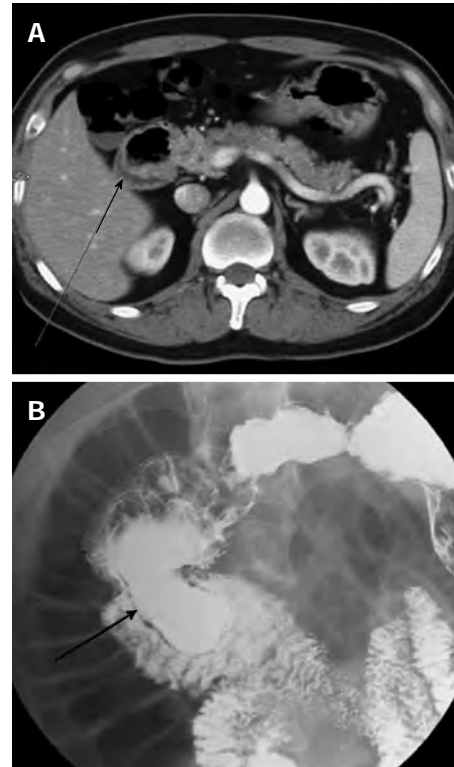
Computed tomography image. A: A high resolution computed tomography image of the abdomen reveals a circumferential cystic lesion (arrow) in the vicinity of the second part of the duodenum; B: Upper gastrointestinal series showing an large elongated sac-like mass (about 10 cm in length, arrow) arising from the second and proximal third portion of the duodenum.
